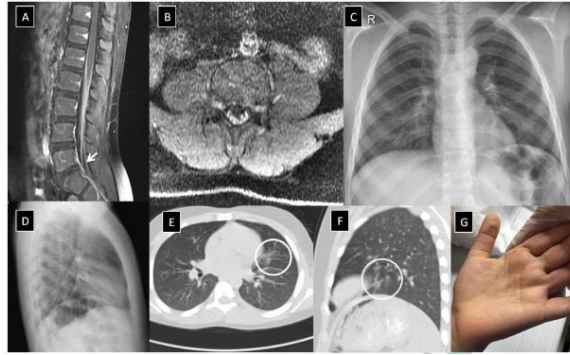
(a,b): Sagittal and axial T1 Fat saturation post contrast magnetic resonance imaging showing cauda equina nerve roots enhancement (white arrow) impressive of GBS; (c,d): X-ray chest PA and left lateral views showing bilateral paracardiac and basal veiling; (e,f): Computed tomography (CT) of the chest showing small patchy subsegmental faint opacity with atelectasis band in the lingula on week after admission (white circles); (g) Morbilliform skin rash over the palmar aspect of the left hand.
